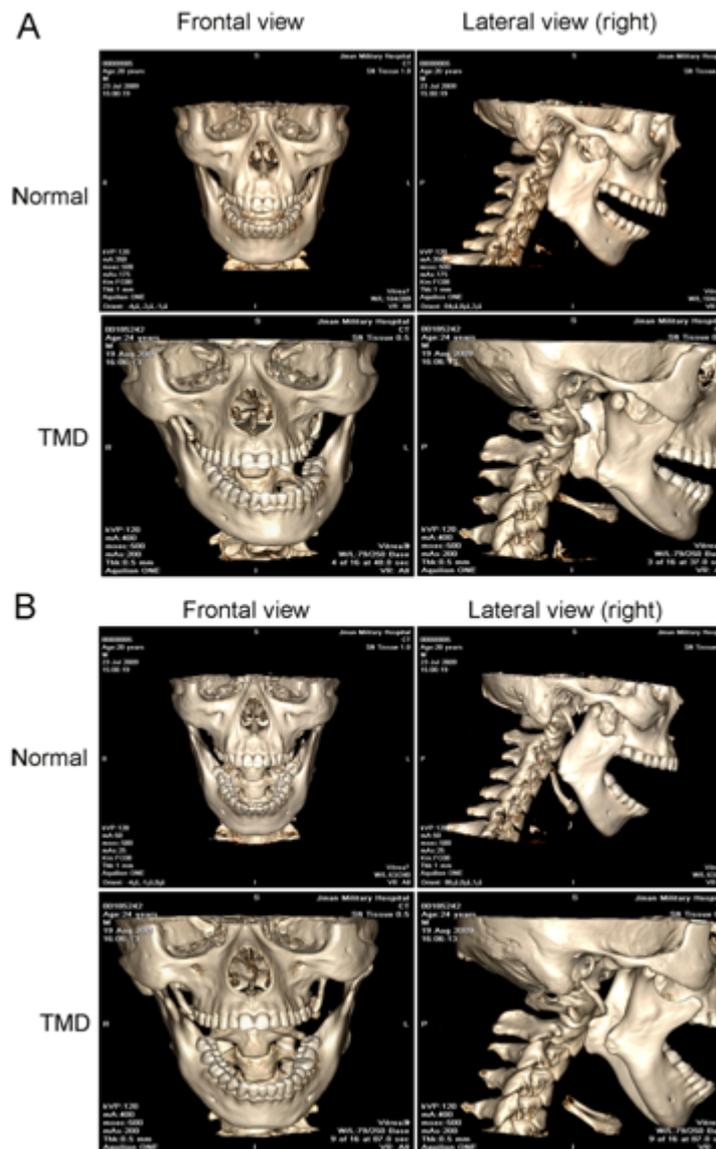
CT images in an open position. A: At 1.5 cm open in frontal view, B: At 4 cm open
